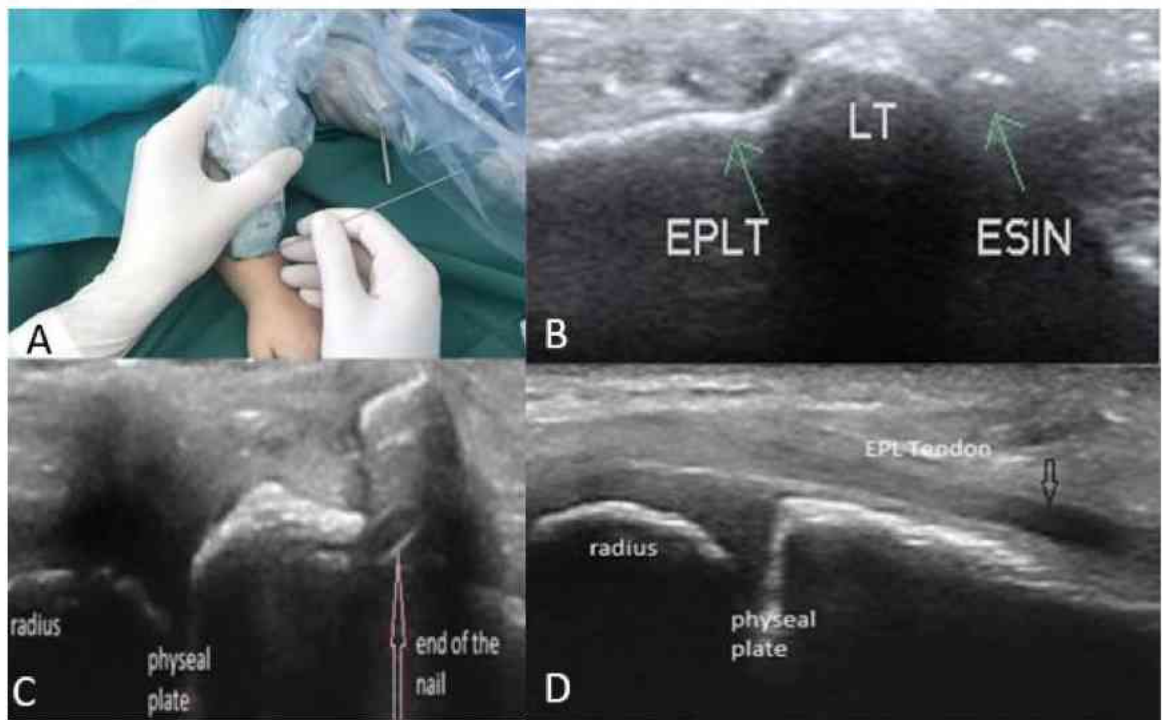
Sonography -assisted aiming of the radial side of Lister's tubercle and intraoperative ultrasound views of the dorsal entry elastic nailing of the radius
